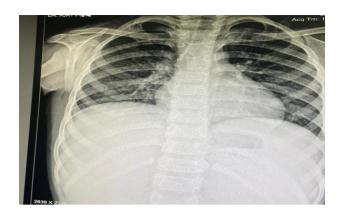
Repeat chest X-ray showing resolution of pleural effusion.
